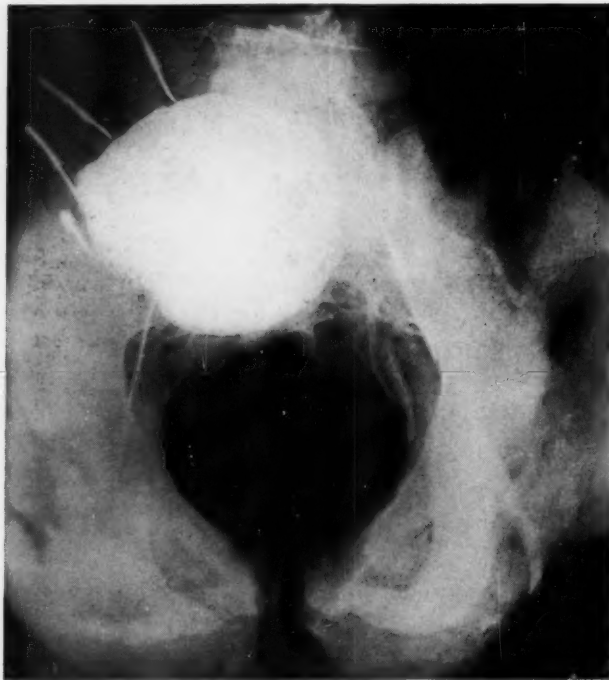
Radiograph shows the outlines of the sac clearly defined after it had been emptied of clot and the clot replaced by a radiopaque medium.
